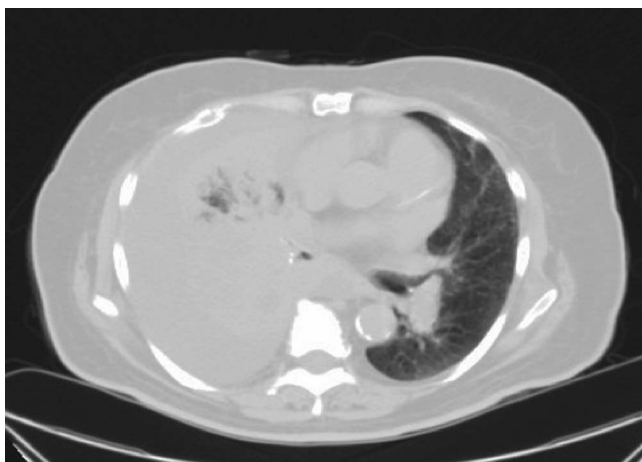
Noncontrast computed tomography scan of the chest shows right lung field and bronchial collapse, pleural effusion, and a 3 × 1.5 cm left hilar mass.
